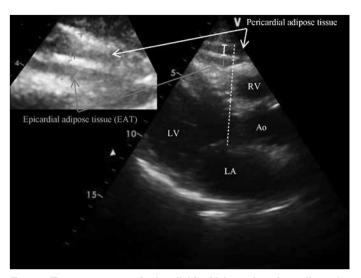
The measurement of epicardial fat thickness by echocardiography EAT - identified as an echo-free space between the myocardium and visceral pericardium from the parasternal long-axis view on 2-dimensional echocardiography, was measured perpendicularly in front of the right ventricular free wall at end-diastole
